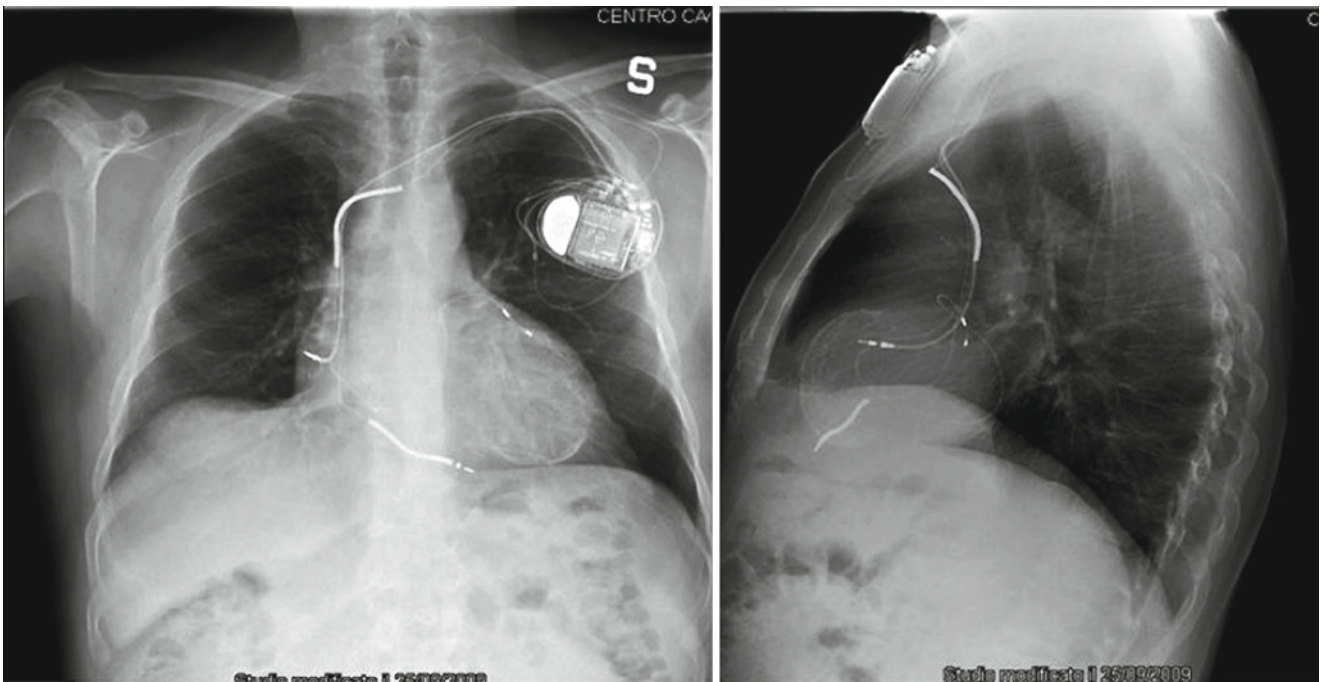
Chest x-ray shows a big calcified thrombus within a large anterior left ventricular aneurism
